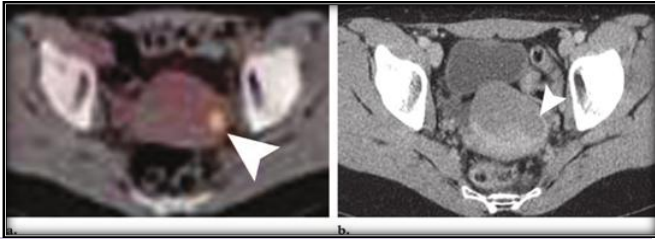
Uterine fibroid imaging. (a) Fused PET-CT showing a hypermetabolic focus (arrowhead) in the uterine body, corresponding to a hypoattenuating fibroid on CT. About 20% of fibroids display this FDG PET pattern. (b) Contrast-enhanced CT demonstrating a focal hypoattenuating fibroid (arrowhead) in the left uterine wall.
